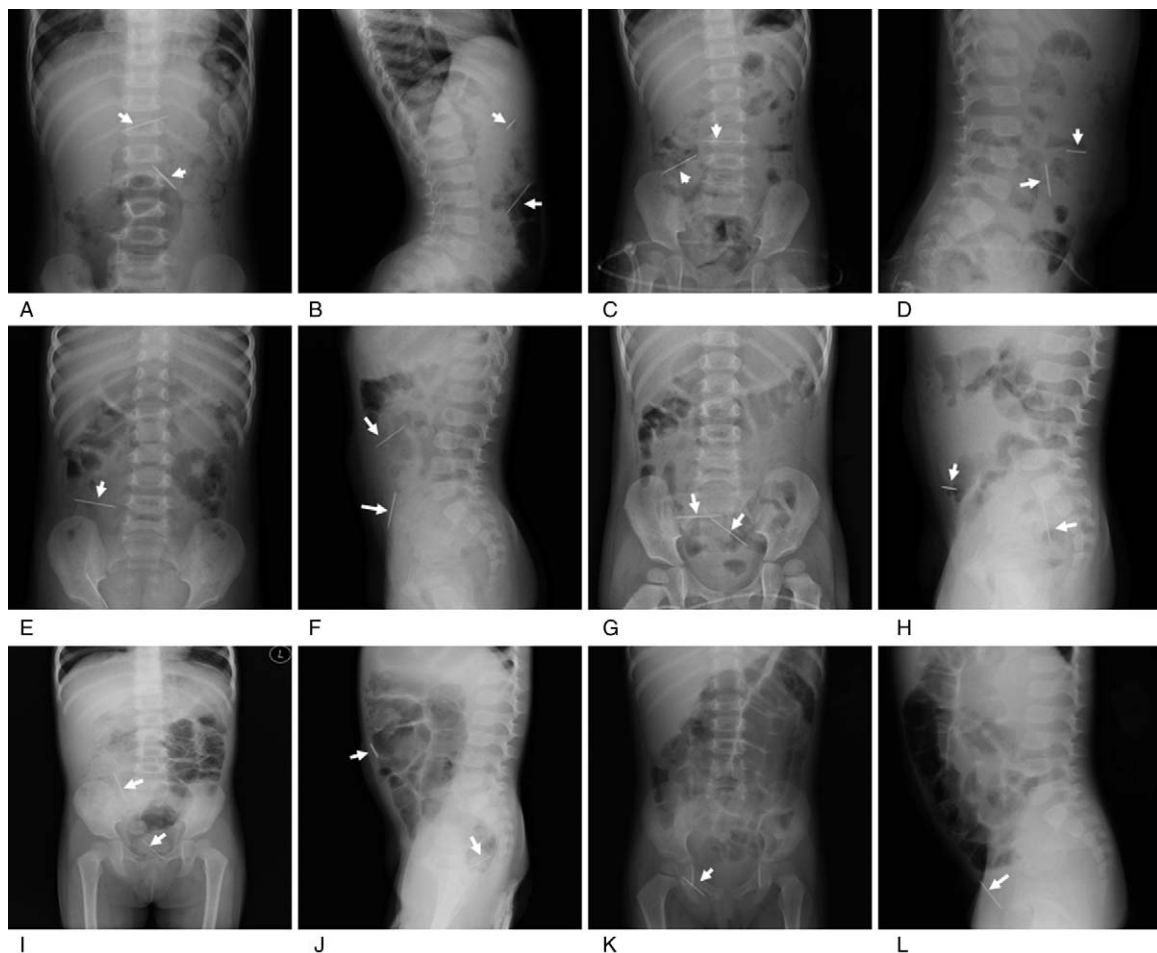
X-ray examination of 2 needle-like foreign bodies located in the abdomen. A,B, At 15 hours after swallowing the needles, positive (A) and side (B) x-ray showed 2 needle-like foreign bodies located at the vertebral T12 and L2 levels in the small intestine (white arrow). C,D, At 24 hours after admission, x-ray showed that the 2 needle-like foreign bodies were located at the T3 and L4–5 levels. E,F, On the 3rd days after admission, 1 needle-like foreign body was located in the vertebral right abdomen (L4–5 levels), whereas the other one was on the right side of abdomen. G,H, On the 6th days, 1 needle-like foreign body was located in the pelvis, whereas the other was near the sacrum. I,J, On the 7th day, x-ray suggested the abdominal intestinal pneumatosis, with a foreign body in the pelvic right front part (I). Lateral x-ray found 1 needle-like foreign body outside of the gut and the other in front of the coccyx (J). K, On the 8th day, x-ray showed that only 1 needle-like foreign body was positioned in the right groin area bowel hernia, and part of the foreign body was located in front of right pelvic cavity. L, On the 9th day, x-ray 1 needle-like foreign body was still positioned in the right groin area bowel hernia, and part of the foreign body was located in the hernial sac. All the x-ray confirmed that there was no free gas in the abdominal cavity.
